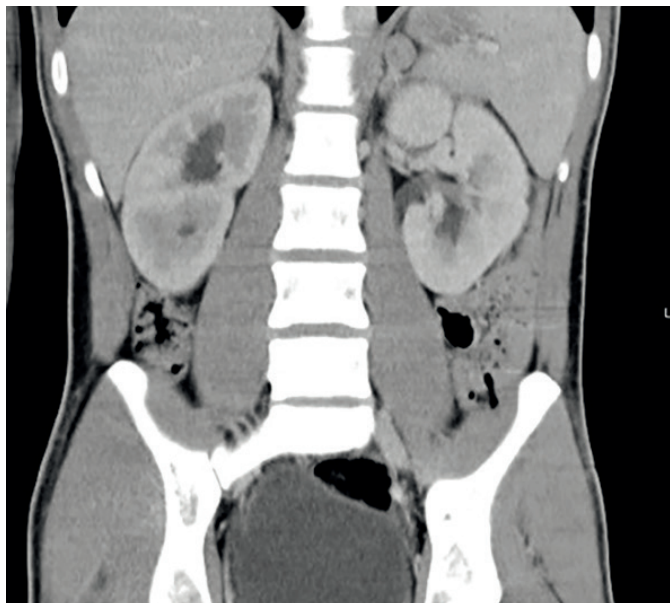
Abdominal-pelvic CT scan showing a small regular hypodense nodule in the left adrenal gland (1.5 × 1.2 cm).
